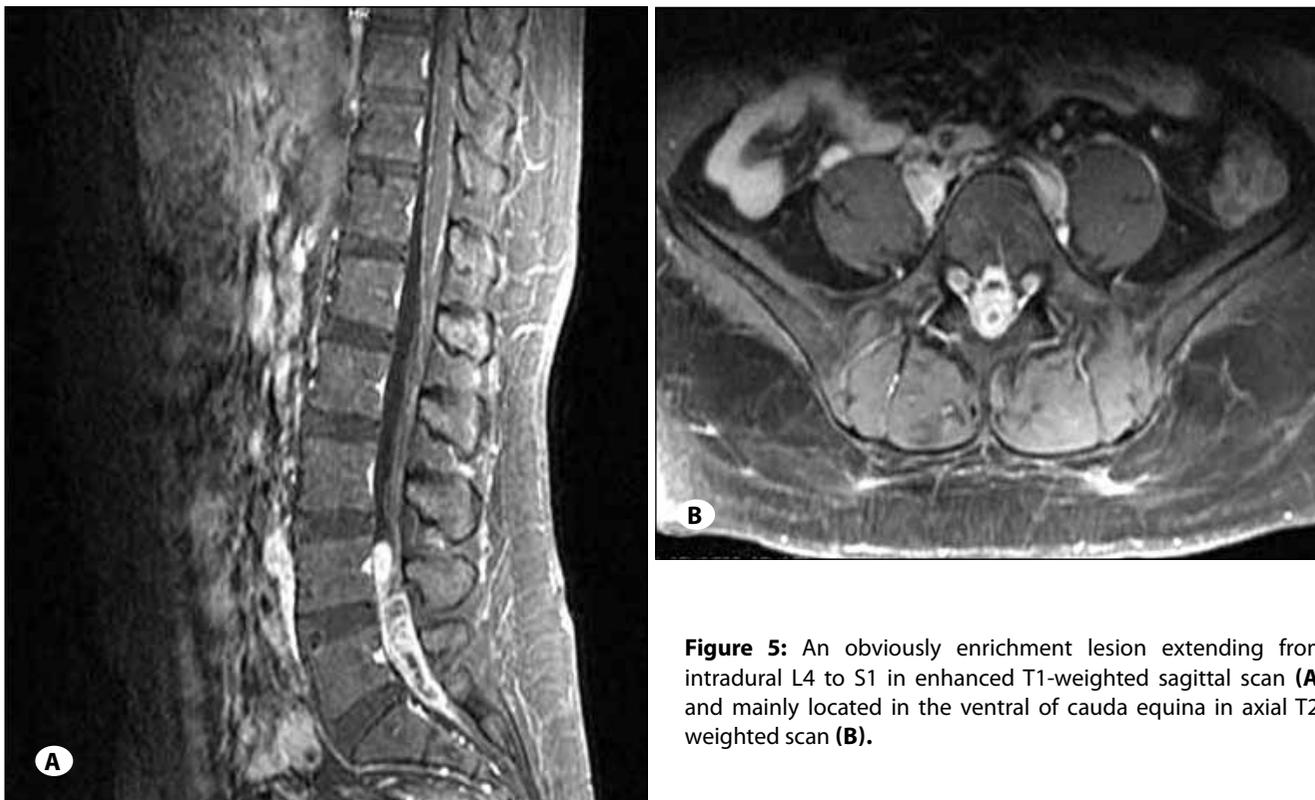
An obviously enrichment lesion extending from intradural L4 to S1 in enhanced T1-weighted sagittal scan (A) and mainly located in the ventral of cauda equina in axial T2-weighted scan (B).
